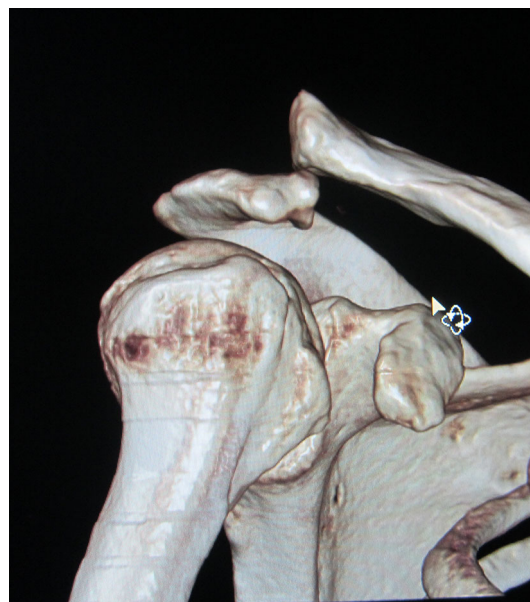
CT scan allowed precise visualization of displacement
